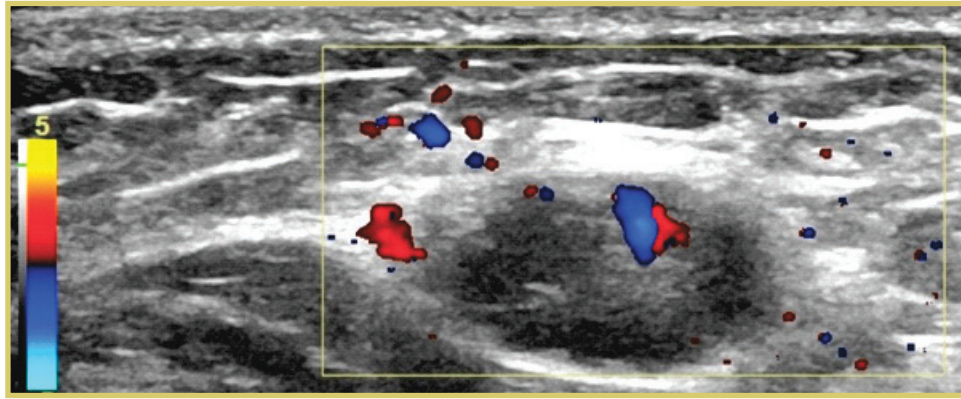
The image shows perineural and intraneural blood flow in the colour doppler of Figure 2.
